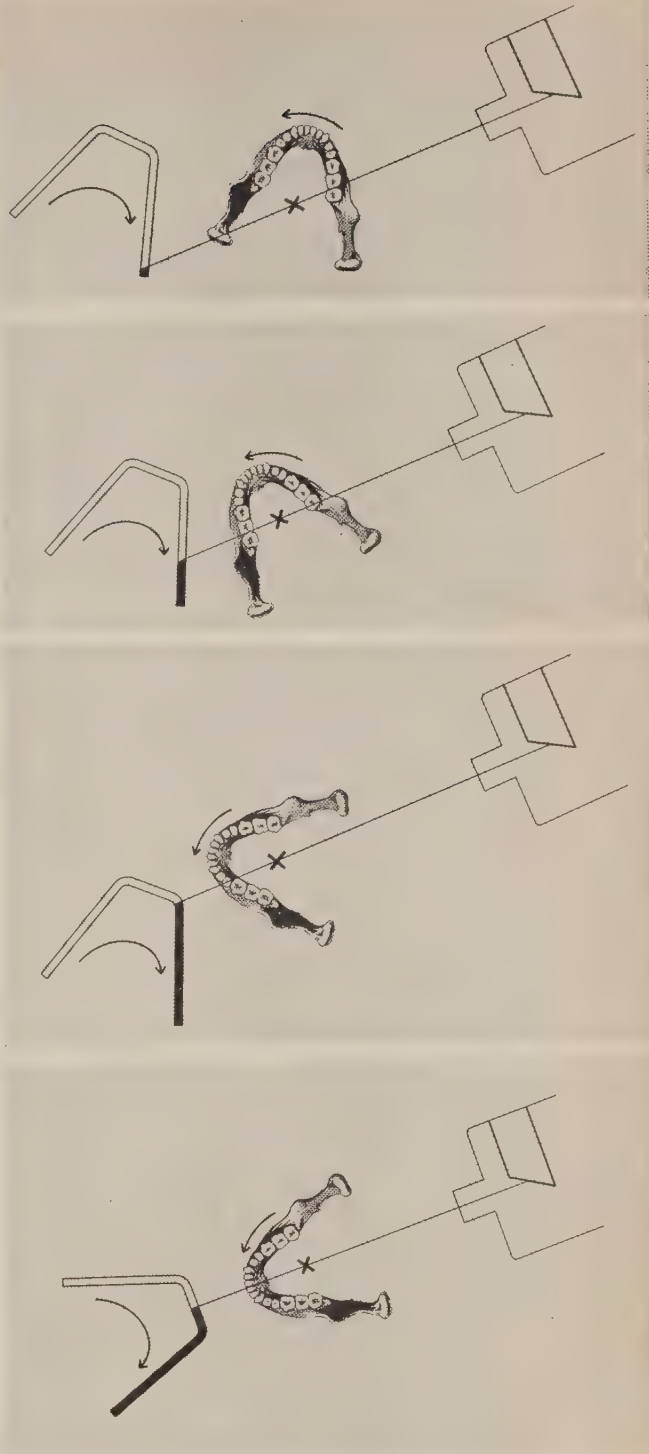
Rotagraphic principle. X-ray source is stationary. Patient and film rotate. Centre of rotational axis is at X. (Updegrave, W.J. D. Radiog. & Photog. 36:75, 1963.)
